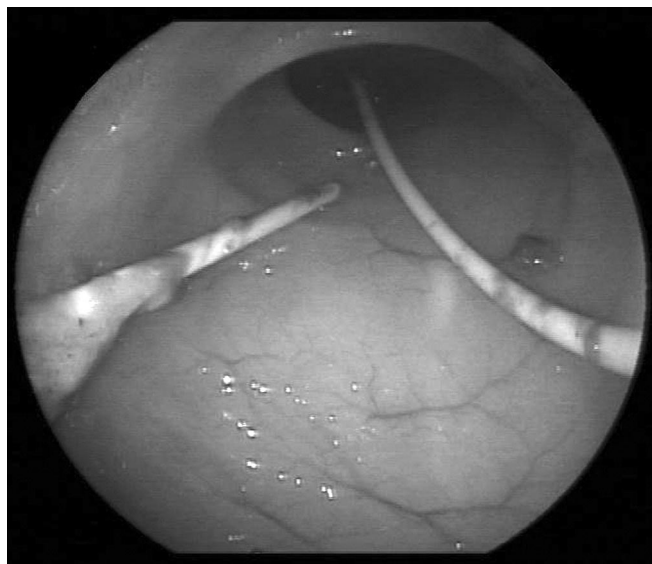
Intraluminal view during colonoscopy verifies the finding of the CT scan.
